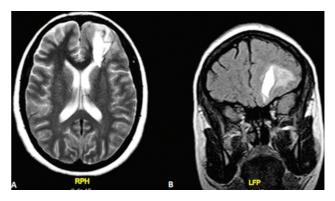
Magnetic resonance image. (A) Axial and (B) sagittal T2-weighted magnetic resonance imaging showing ischemic injury with hemorrhagic transformation in the left frontal region and perilesional
